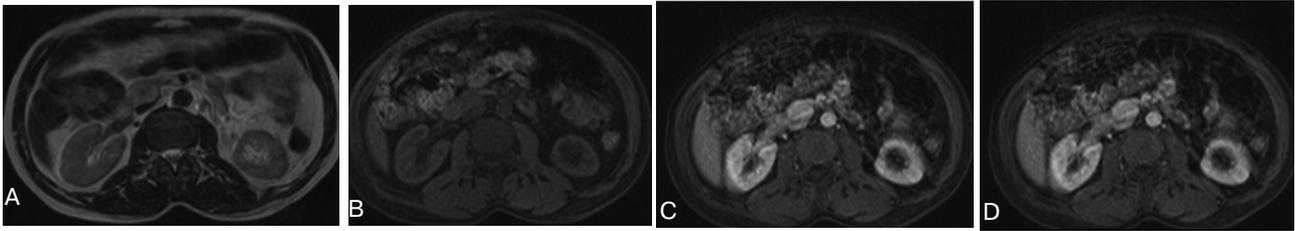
Insulinoma. A. T2-weighted MR image shows a well-circumscribed slightly hyperintense lesion in the head of pancreas. B. On T1-weighted MR image the lesion appears slightly hypointense. C. Lesion shows clear enhancement on a postgadolinium T1-weighted sequence in early arterial phase image. Figure part D is the portal phase image
